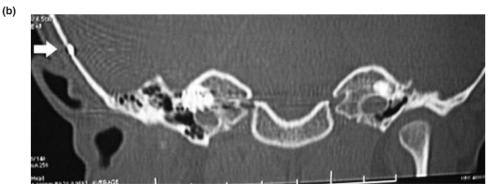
Computed tomography shows migration the reference electrode to dura mater, a) Axial plane (white arrow), b) Coronal plane (white arrow)
